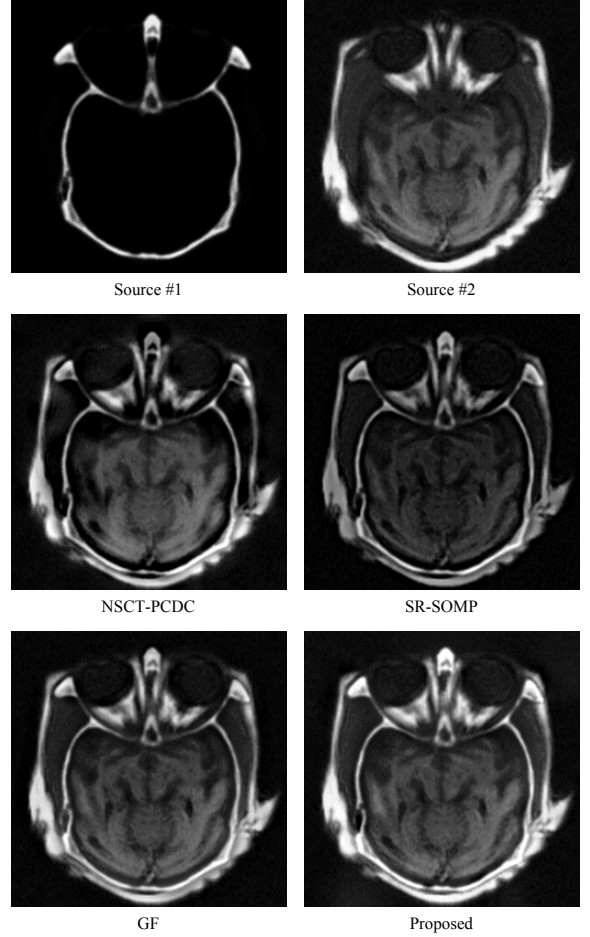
Fusion results of different methods on a pair of CT and MR images.
